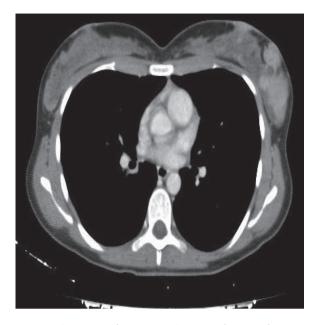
Contrast enhancement CT scan showing the upper outer quadrant replaced by several solid, uneven nodules, the biggest of 5 cm, which converge among themselves, and extended to subcutaneous tissues.
